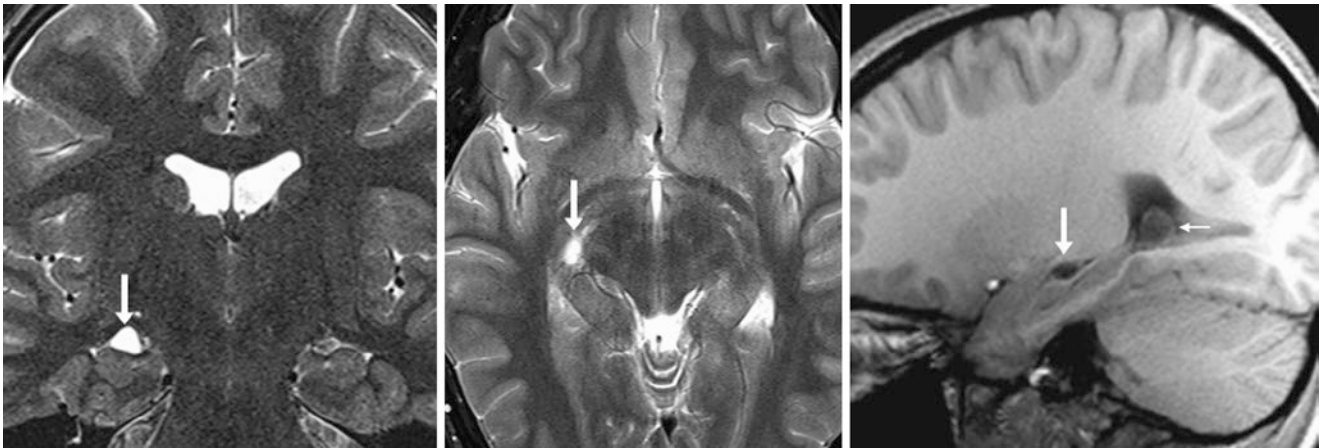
A 12-year-old patient with a small CFC (*arrows*) on a 3 T MRI with coronal T2WI (*left*), axial T2WI (*middle*), and sagittal T1WI (*right*). The cyst can be localized to within the choroidal fissure on sagittal T1WI (*right*). Note a normal xanthogranuloma within the atrium of the right lateral ventricle (*tiny arrow, right*)
